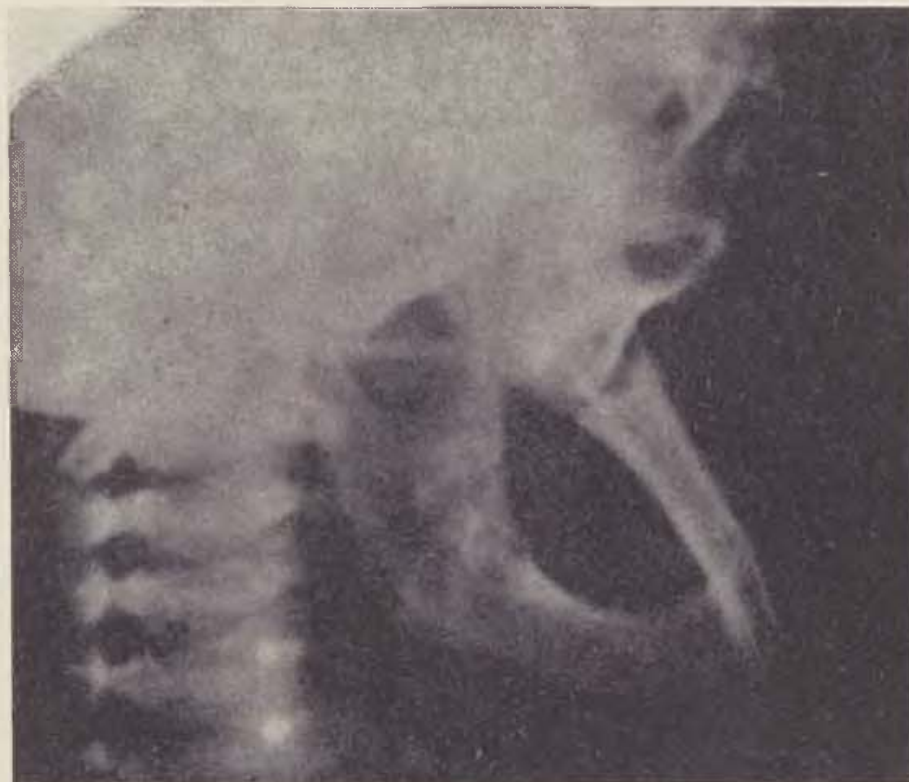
M. K. x-ray of the teeth-less jaw at the age of 3½ years.
